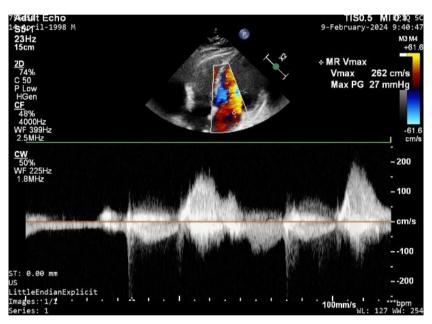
Apical four-chamber view with continuous wave doppler at the mitral valve showing mitral regurgitation with a peak velocity 262 cm/sec and pressure gradient of 27 mmHg.
